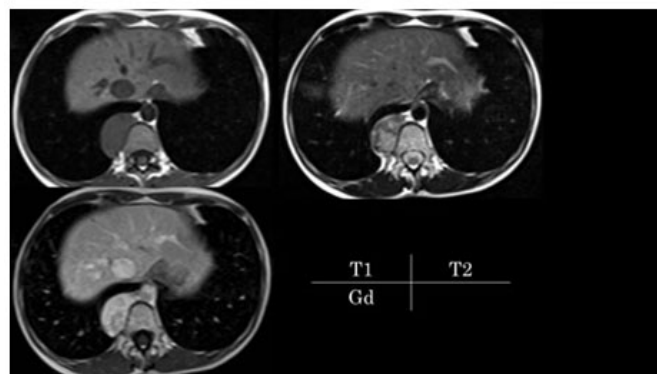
Magnetic resonance imaging in case 2 showing low-signal intensity on T1-weighted imaging, heterogenous intensity on T2-weighted imaging, and a heterogenous pattern on gadolinium-enhanced imaging.
